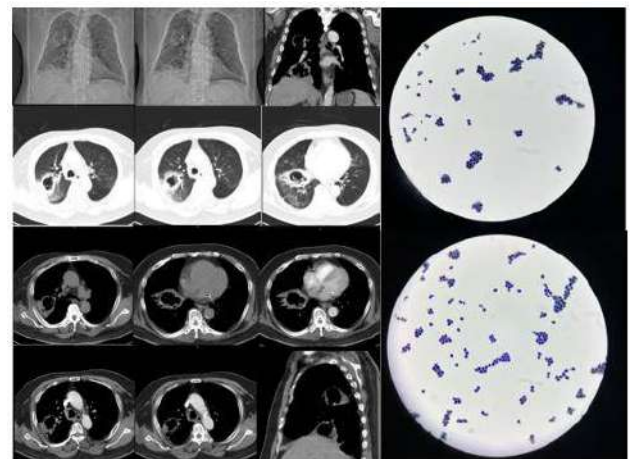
(a) CT-scan showed consolidations and a nodule with irregular wall thickening and cavitation; (b) microbiology findings showed *Candida Sp.* and continued with sputum culture showed *Candida glabrata*.
